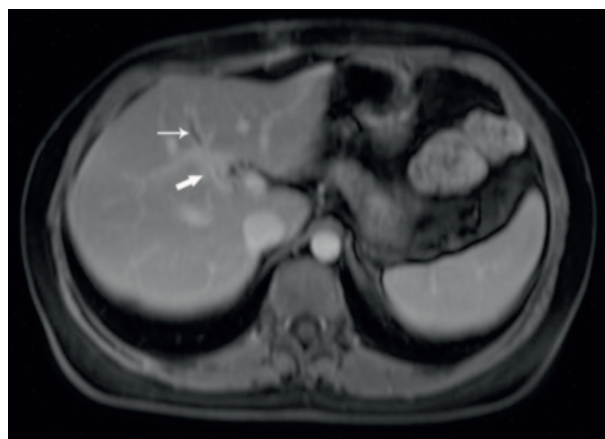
Contrast-enhanced axial T1W magnetic resonance image of the liver at the level of the ligamentum teres shows that saccularly dilated umbilical portion of the right anterior portal vein (thin white arrow) finally joins to the ligamentum teres (thick white arrow)
